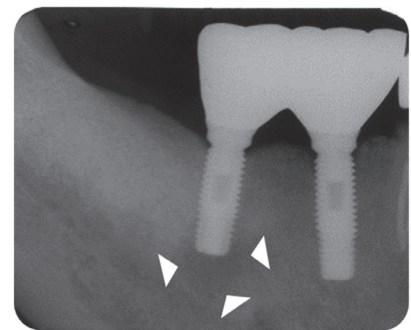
Periapical radiograph after 6 years of implant placement still showing IPL at the apex of the implant of the mandibular right first molar area. Arrow heads depict the extent of IPL.
